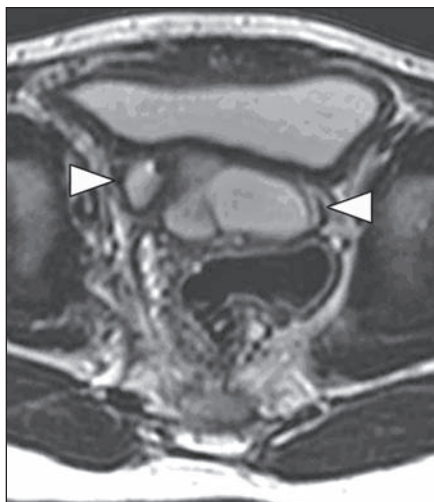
4-year-old girl with multiple genitourinary anomalies after repair of cloacal anomaly. Axial T2-weighted MR image of pelvis shows two hemivaginas (arrowheads) with retained fluid (hydrocolpos).
